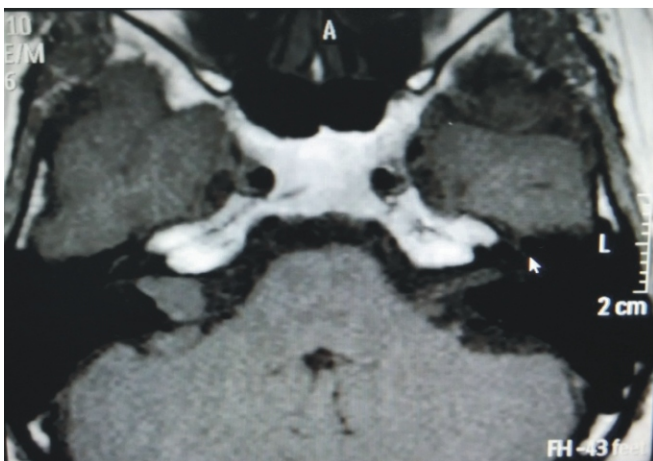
T2 weighted FLAIR MRI in coronal view showed hyperintense lesion in the right intracanalicular portion of the internal auditory meatus extending to the cerebellopontine angle (arrow).
